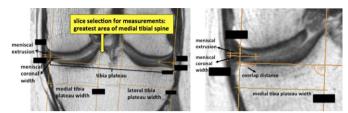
Measures on coronal 3T intermediate weighted knee MRI (eFilm 3.4 software).
